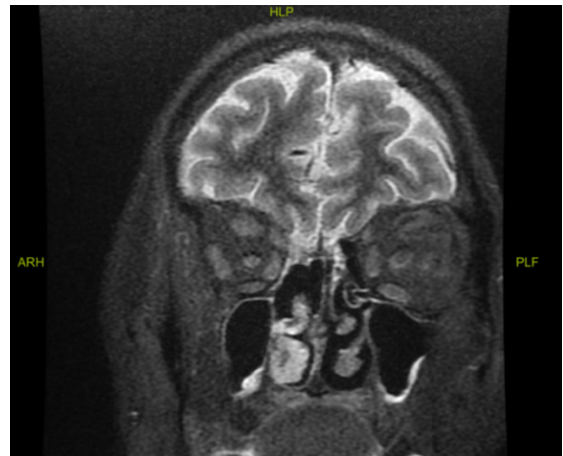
Regression of the existing lesion from the previous imaging studies in the orbital T1-weighted MR imaging scan from the coronal view, six months post-chemotherapy
